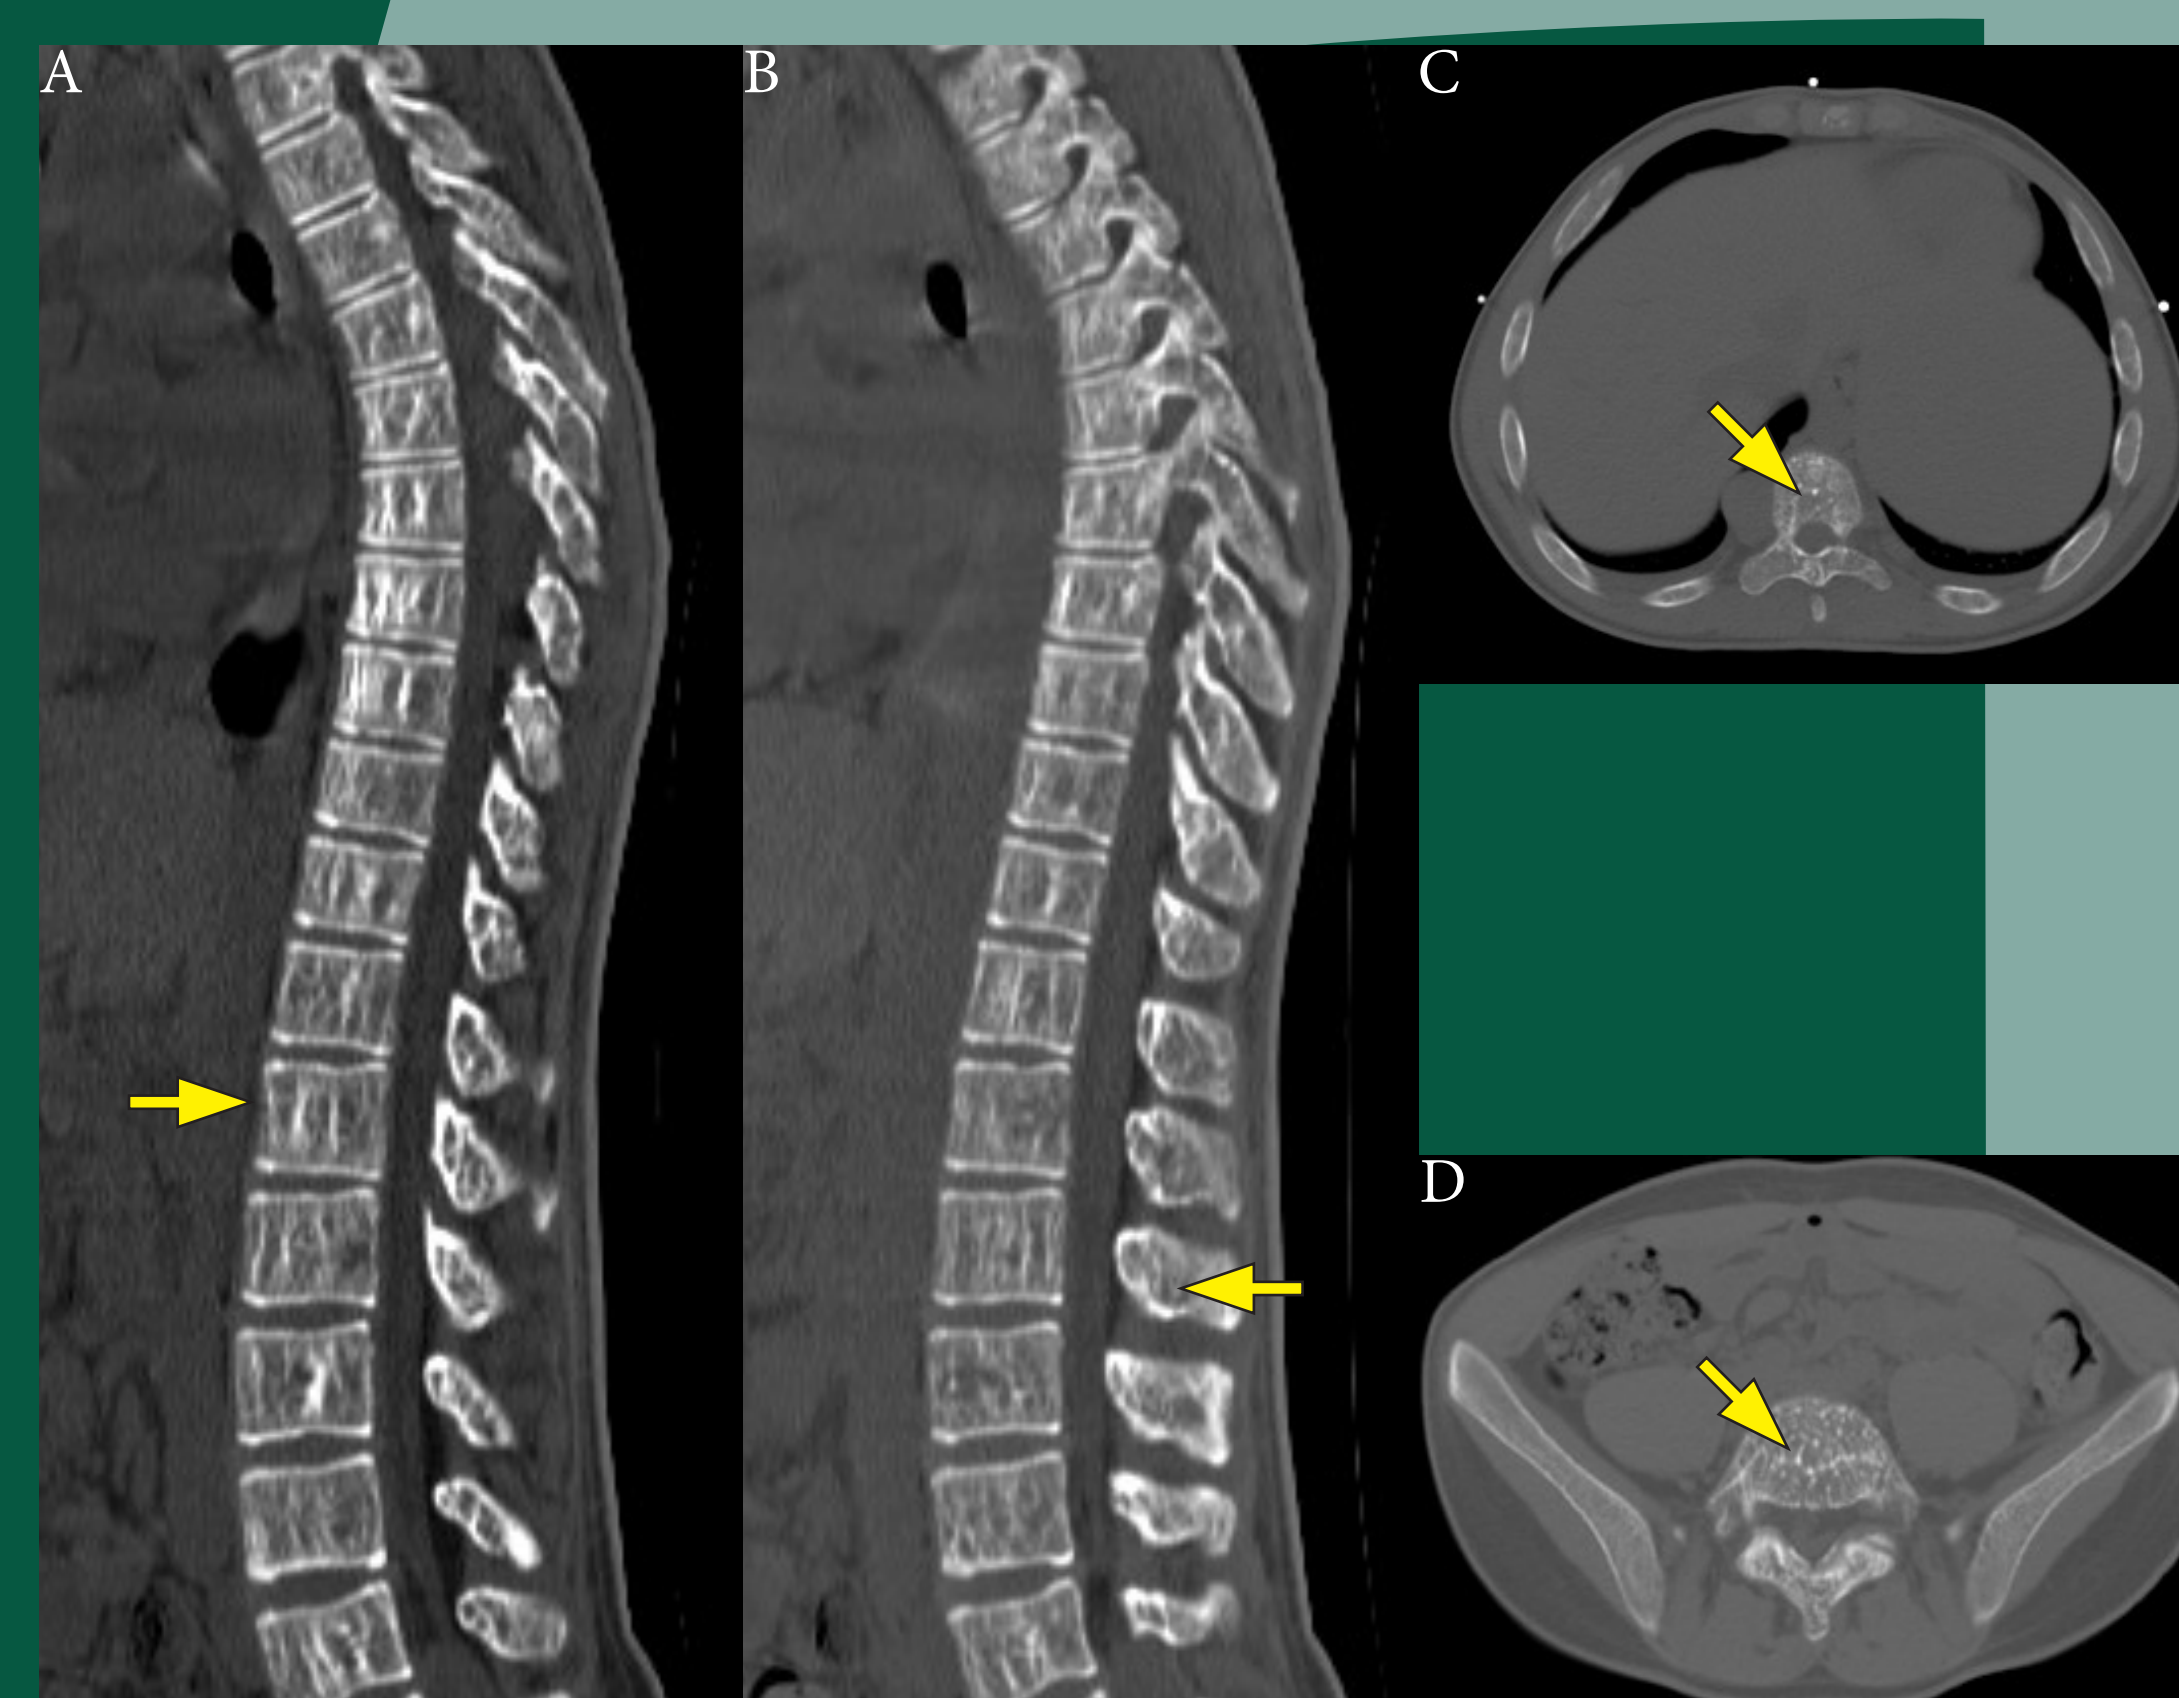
CT of the spine. (A-B) sagittal projections showing expansion of posterior elements and spinous processes of multiple cervical, thoracic, lumbar vertebral bodies secondary to expansion of bone marrow (arrows). Axial projections at the level of the thoracic spine (C) and pelvis (D) demonstrating expansion of bone marrow (arrow).
